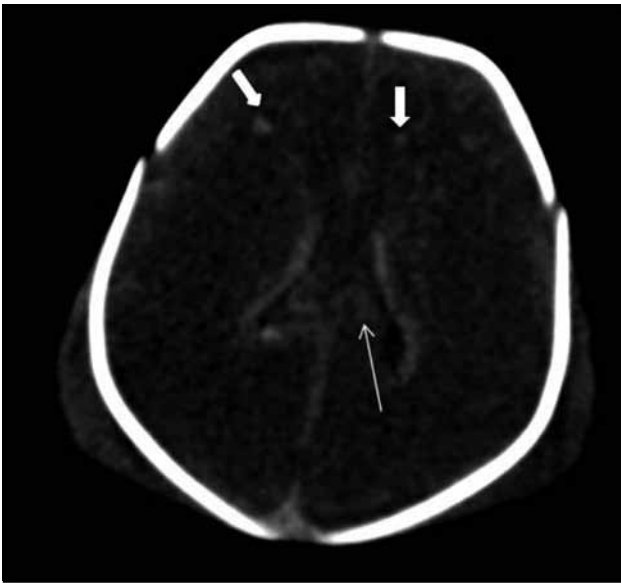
Computed tomography of the brain of the surviving twin 2 days after birth showing diffuse cerebral oedema with generalised hypo-attenuation of brain parenchyma, intraventricular haemorrhage (thin arrow), and petechial haemorrhages in both frontal lobes (bold arrows)
